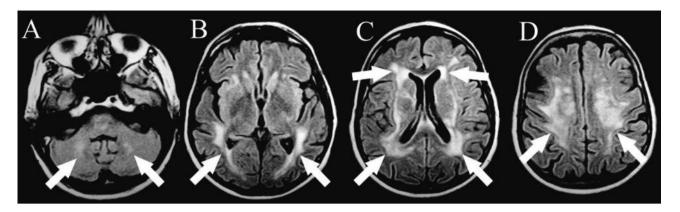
Brain MRI showing very slight bilateral white matter changes in the cerebellum (A) and diffuse supratentiorial posterior-dominant leukoencephalopathy on FLAIR sequences (B-D).
